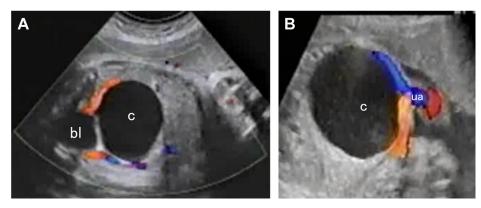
Coronal color Doppler US images (A, B) demonstrate the cyst (c) separating the two umbilical arteries (ua) at the base of the umbilical cord. bl: bladder.
